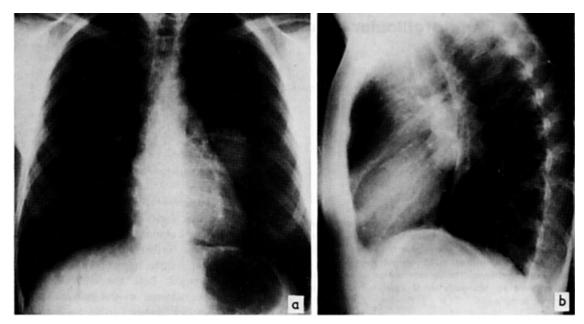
a-b. Chest X-rays taken preoperatively showing the mediastinal tumour in the left lung hilus.
